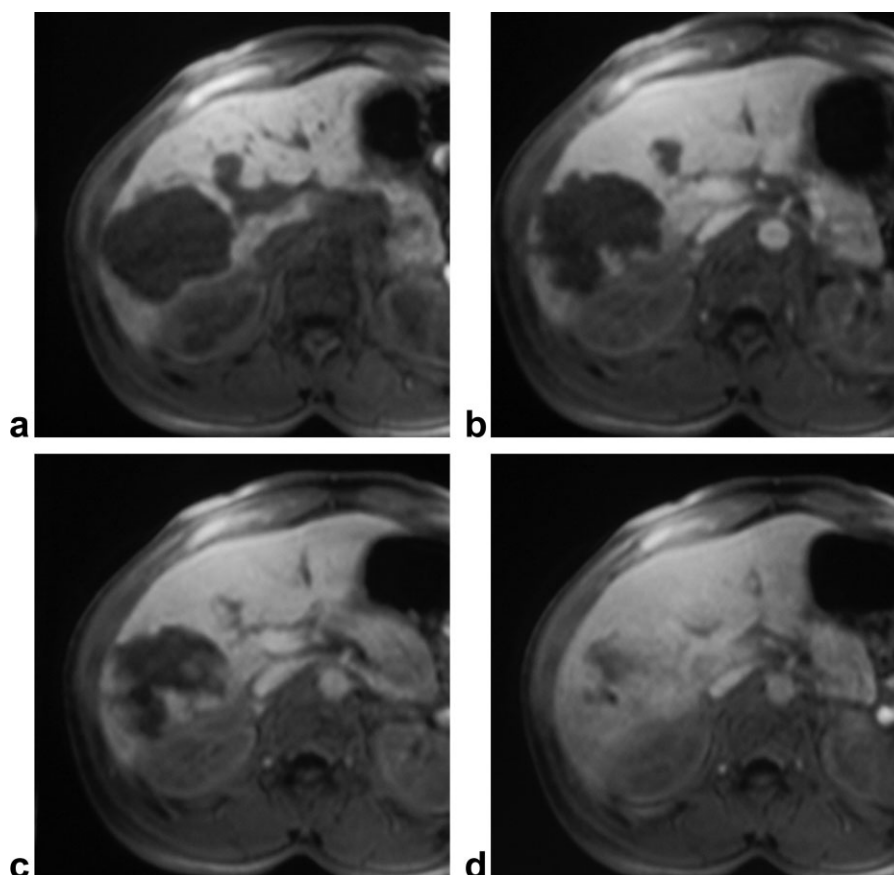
a-d: Hepatic hemangioma. On the unenhanced T1-weighted VIBE acquisition (a), a large nodule hypointense versus surrounding right liver lobe parenchyma, is appreciable. After slow bolus Resovist administration, nodule shows a slow fill-in phenomenon in the arterial and equilibrium phases (b,c), becoming almost isointense versus surrounding parenchyma on the 10-min T1-weighted acquisition (d).
